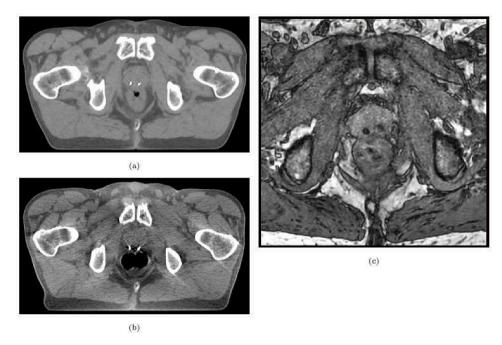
Clinical case from one of the patients treated in the pilot phase of PRO-PROTON 1. The patient has Gold Anchor GA200–10B (Naslund Medical AB, 10 mm long and 0.4 mm in diameter) implanted. The markers are visualized on (a) CT, (b) CBCT and (c) MR.
